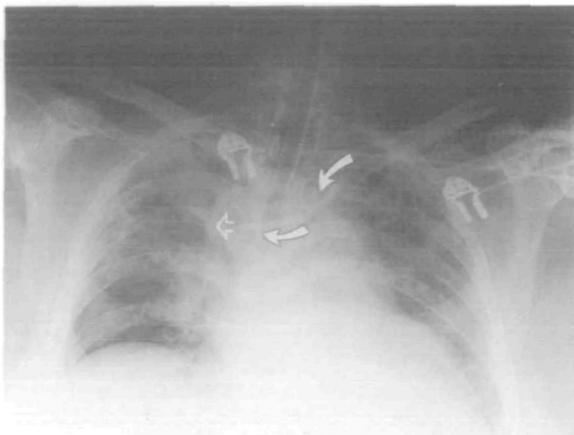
Chest radiograph showing the curve taken by catheter (closed arrows) inserted from the left side and its tip (open arrow).
